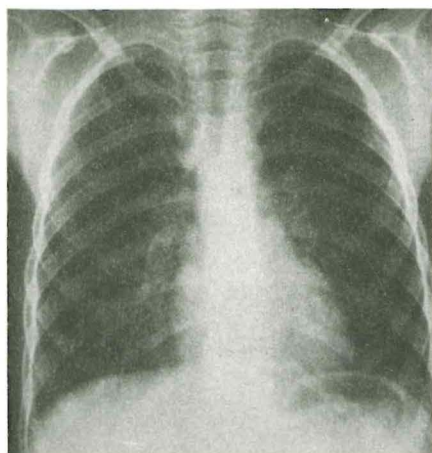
Chest X-ray film of patient 2 at the time of presentation showing diffuse bilateral infiltrates.
